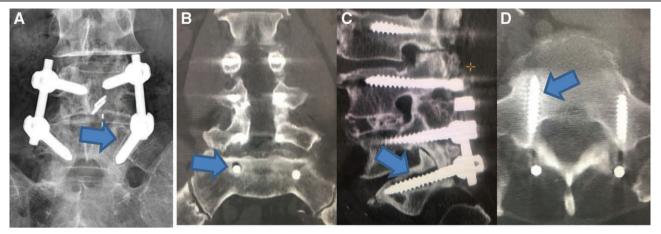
A, Anteroposterior X-ray showed radiolucent zone and double halo around the screw (blue arrow) at left L5. B–D, CT scan showed typical radiolucent zone and double halo around the screw at right S1 which indicate screw loosening.
